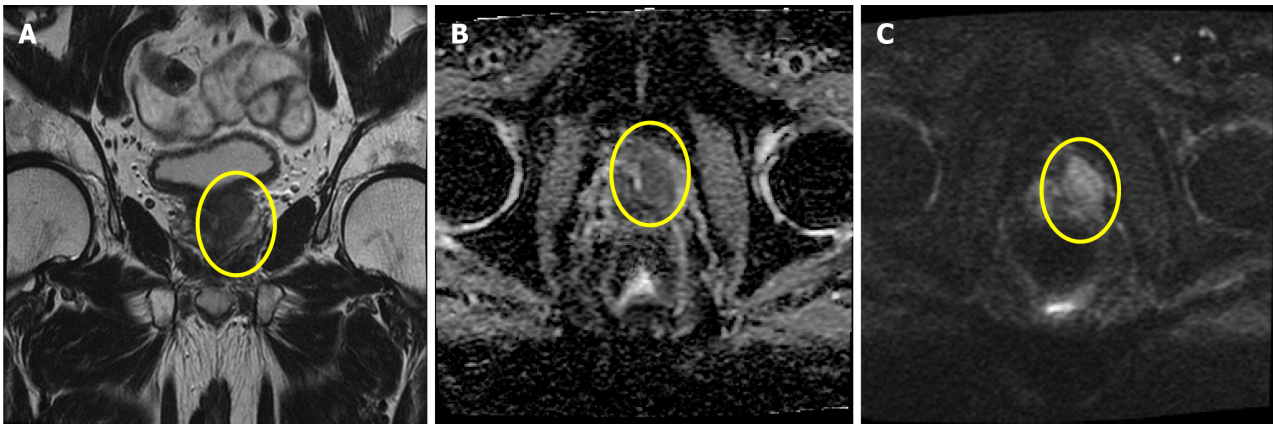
Image of the pelvis obtained during follow-up with magnetic resonance imaging. A: A 2.4-cm lesion with low T2 signal is observed in the posterolateral portion of the left transitional zone; B: Apparent diffusion coefficient of the lesion with low signal; C: Increased diffusion tensor imaging signals are observed.
